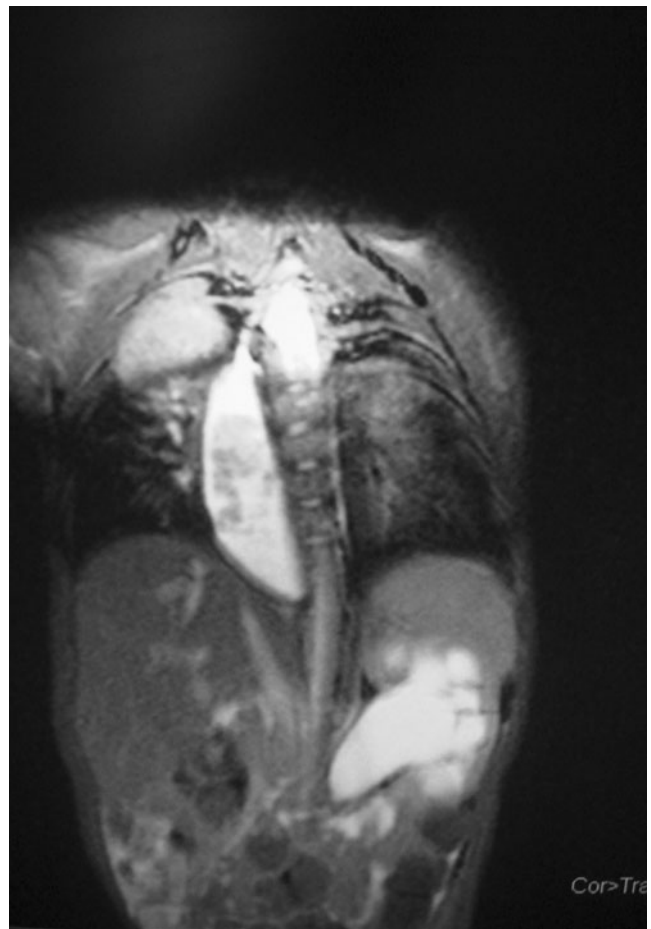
Magnetic resonance imaging showing mega-esophagus and left hydronephrosis due to obstruction of the pelvi-ureteric junction
